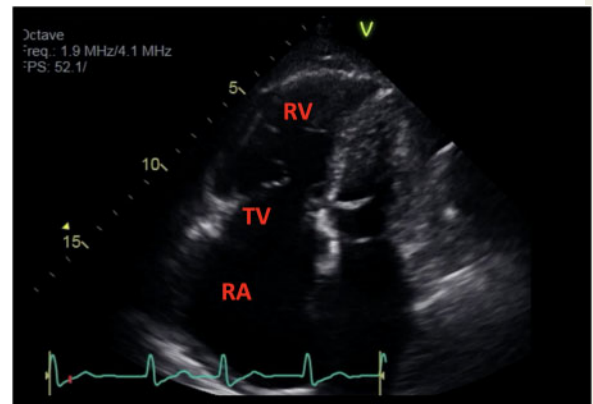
Apical 4 chamber view showing anterior displacement of the septal leaflet along with a significant coaptation defect between the septal and anterior/posterior tricuspid valve leaflets.
